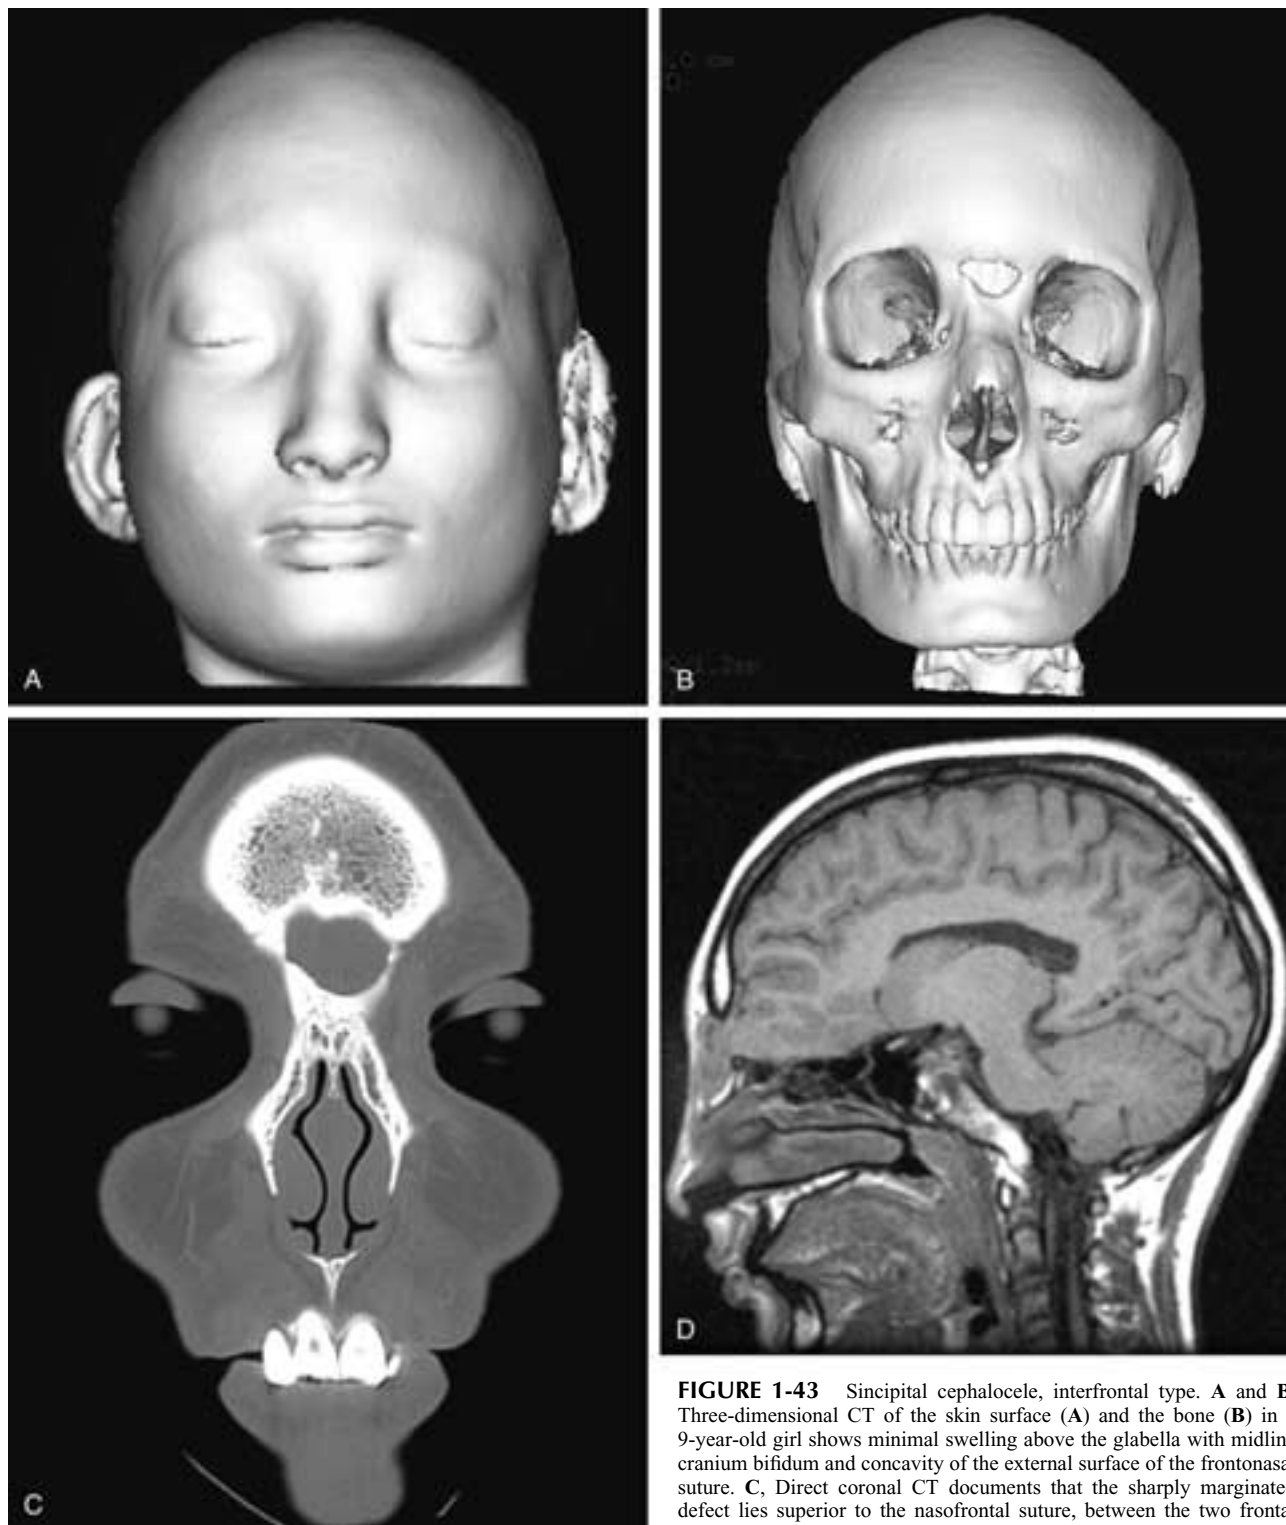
Sincipital cephalocele, interfrontal type. A and B, Three-dimensional CT of the skin surface (A) and the bone (B) in a 9-year-old girl shows minimal swelling above the glabella with midline cranium bifidum and concavity of the external surface of the frontonasal suture. C, Direct coronal CT documents that the sharply margined defect lies superior to the nasofrontal suture, between the two frontal bones. D, Sagittal T1-weighted MR image shows fullness at the glabella and herniation of intracranial content through the cranial defect above and external to the nasal bones and nasal capsule.
